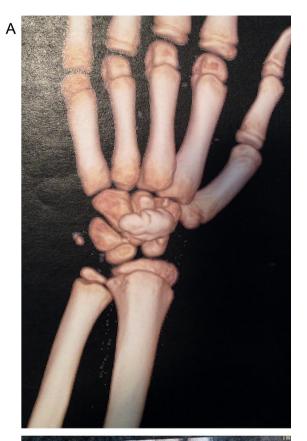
A and B: CT scan with 3D reconstruction.
